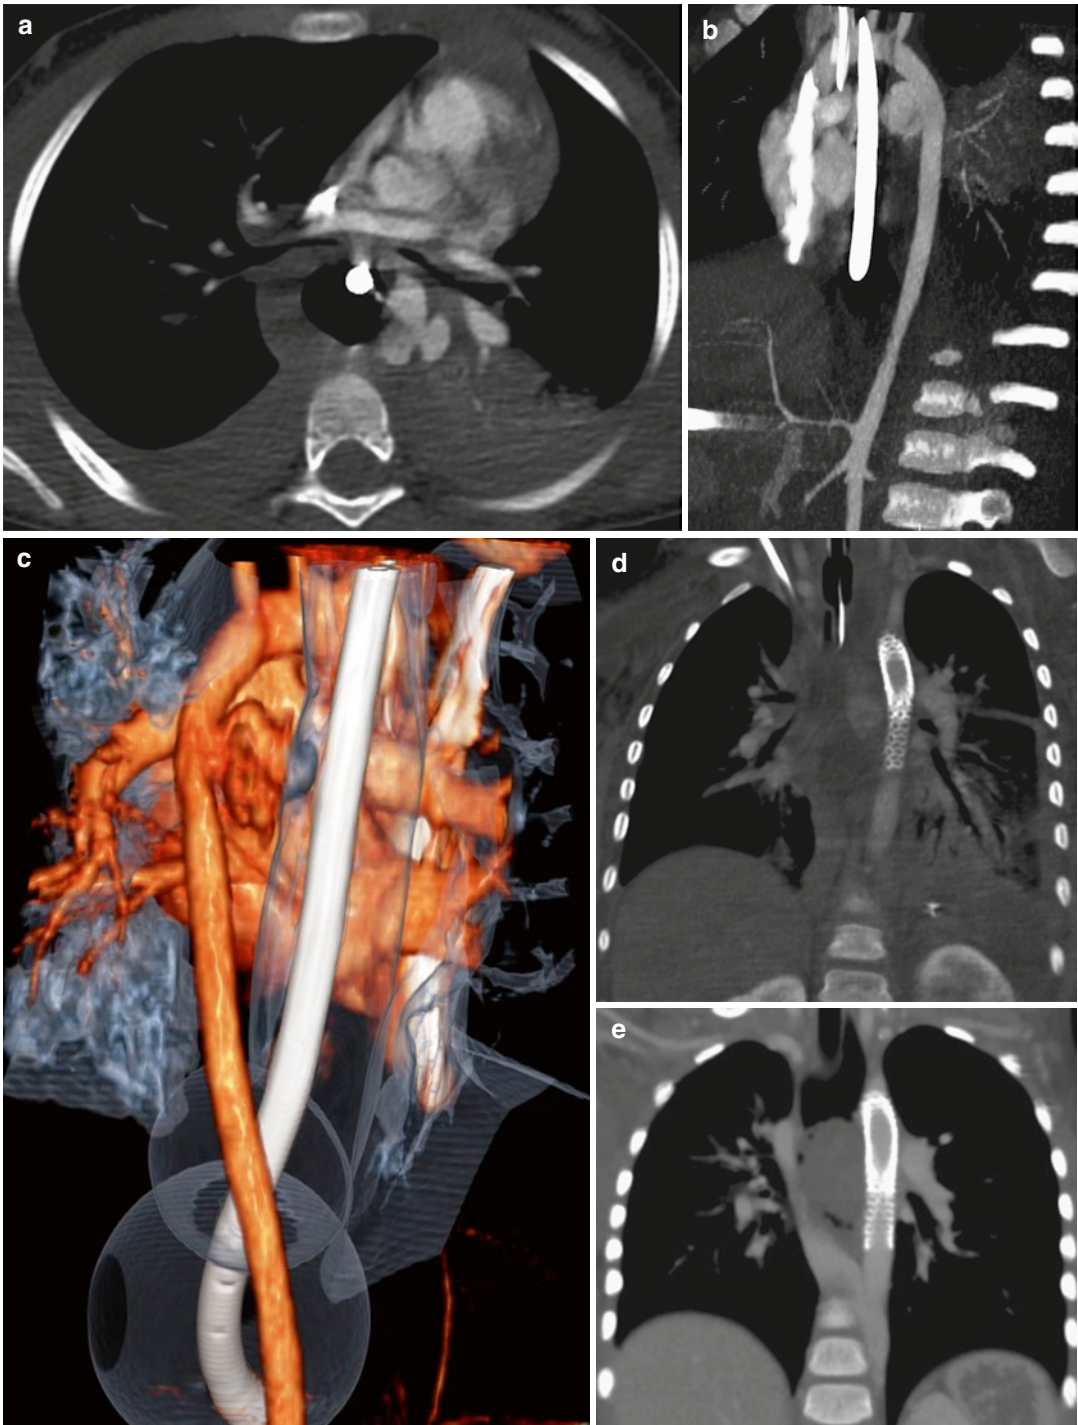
Primary AEF in a 4-year-old patient presenting with massive hematemesis. Axial CT image (a), sagittal MIP (b), and VR posterior view (c) demonstrate a large pseudoaneurysm. Esophagus is distended by an insufflated Sengstaken–Blakemore balloon (c). Immediately
